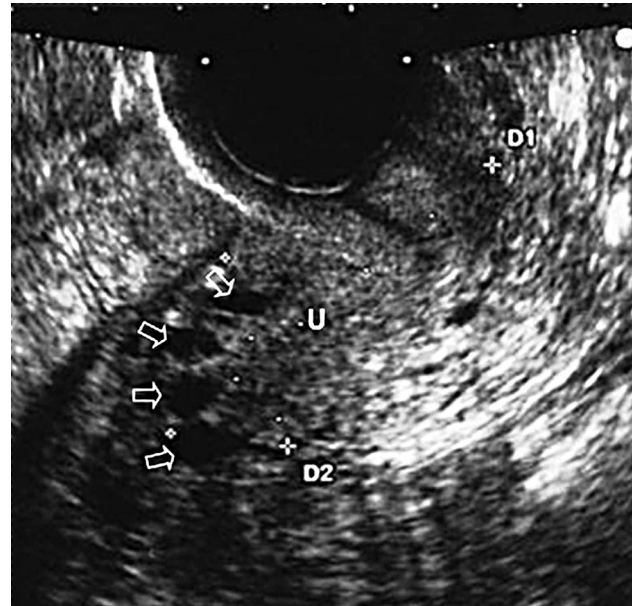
An exemplificative ultrasound scan of the uterus (U), performed by a 6.5-MHz transvaginal probe, which shows multiple anechoic round and oval areas, 5 mm in maximum diameter (arrows), into the myometrium at level of the uterine corpus/fundus (D1 and D2).
